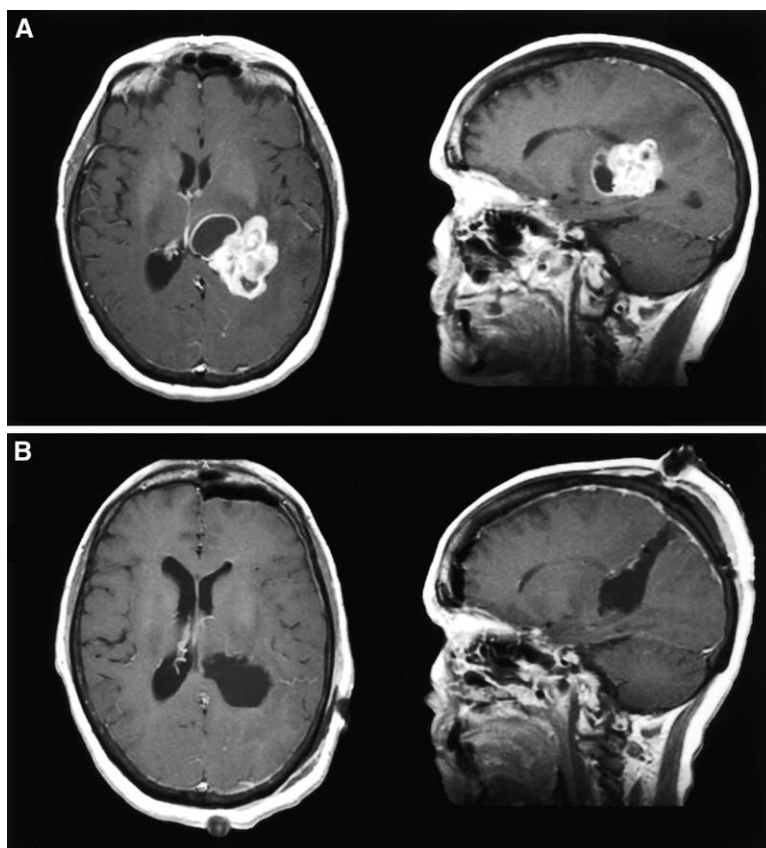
(A) Preoperative axial (left) and sagittal (right) contrast-enhanced MRI scans of a 50-year-old man with known renal cell carcinoma and a left atrium/trigone lesion. (B) Corresponding immediate postoperative MRI scans after a gross total resection via a transcortical superior lobule approach. The trajectory of this approach is evident.
